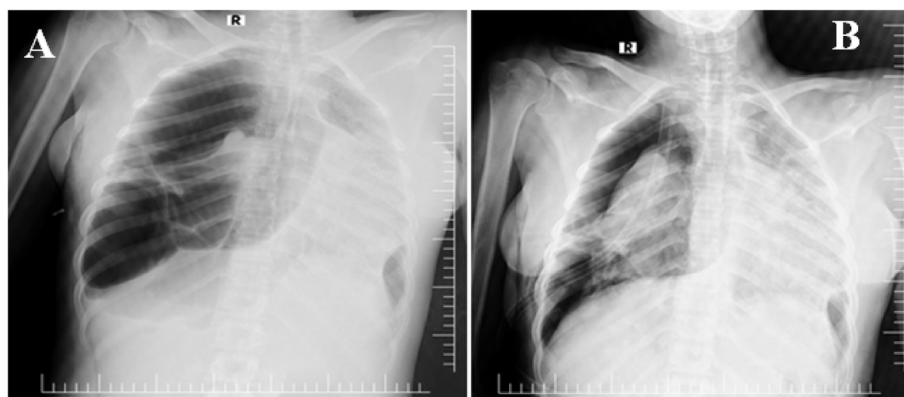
Posterior-anterior chest X-ray shows tension pneumothorax on the right side with left-side consolidation and mediastinal shifting (A). Chest X-ray after chest tube insertion. There is expansion on the right lung (B)
